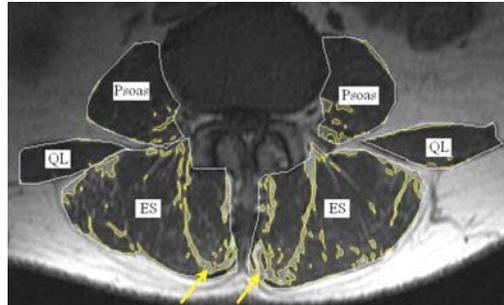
Axial T1-weighted MR image at the L3/4 disc level. The psoas, quadratus lumborum (QL) and erector spinae (ES) muscles are marked. The more hyperintense areas within the boundaries represent adipose tissue (arrows), while the remaining tissue represents lean muscle.
